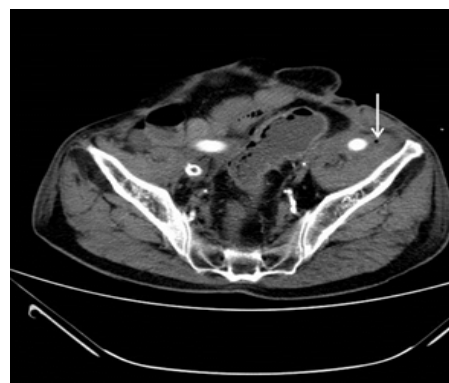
Computed tomography scan demonstrated fluid and air surrounding the left limb of the aortobifemoral graft (arrow).
